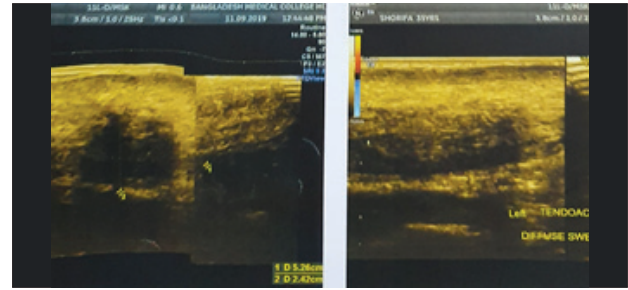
Ultra sonogram view of the Achilles tendon xanthomas in both legs.
